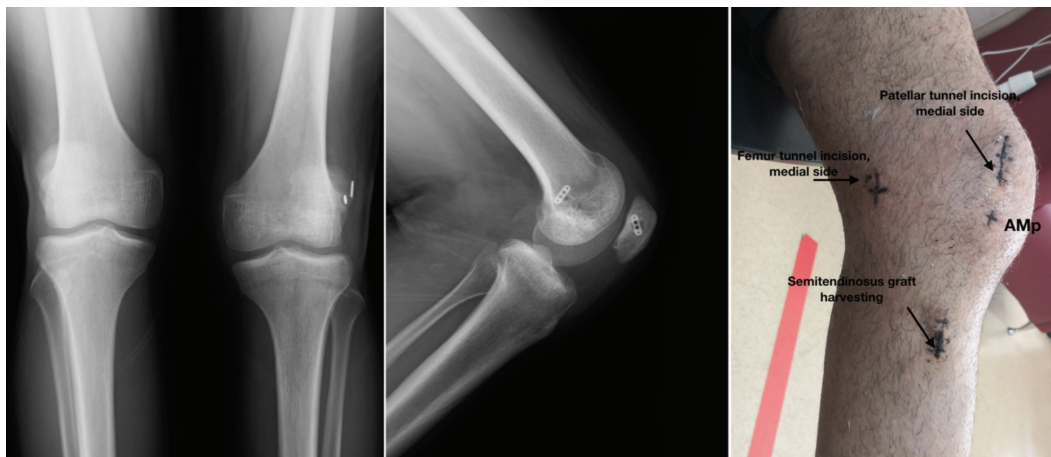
D. Postoperative X-ray image of suspension devices and tunnels, skin incisions of surgical technique from the medial aspect
